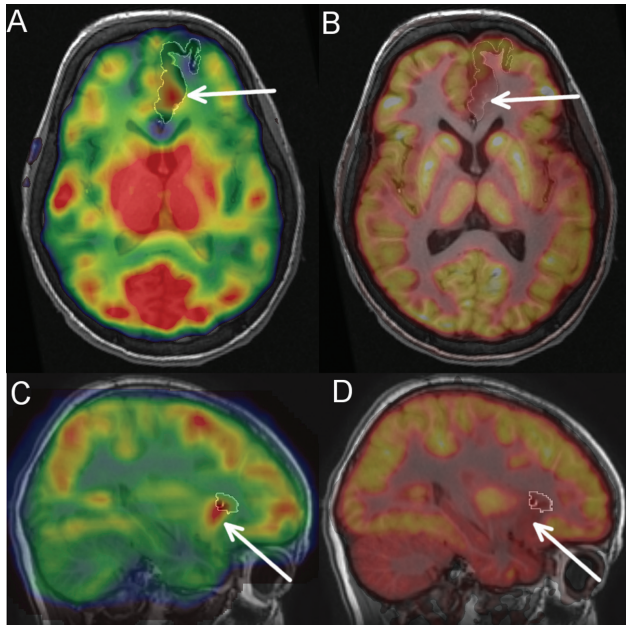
Spatial relation between surgical and positron-emission tomography (PET)-based region of interests (ROIs). Regional homogeneity (ReHo) maps (A, C) and standardized uptake value (SUV) maps (B, D) overlaid on T1 preoperative images, with area of surgery delineated using white contours. Arrows indicate the hypometabolic regions on PET. In patient 6 (axial plane in A, B), the resected region is much larger than the PET hypometabolic area. The PET hypometabolic area (sought to match the focal cortical dysplasia area) is characterized by a higher ReHo and lower SUV than the whole ROI. In patient 4 (sagittal plane in C, D), the resected region is smaller than the PET hypometabolic area, to decrease the risk of postsurgical deficits. Consequently, the resected region does not include the whole area of high ReHo and low SUV.
